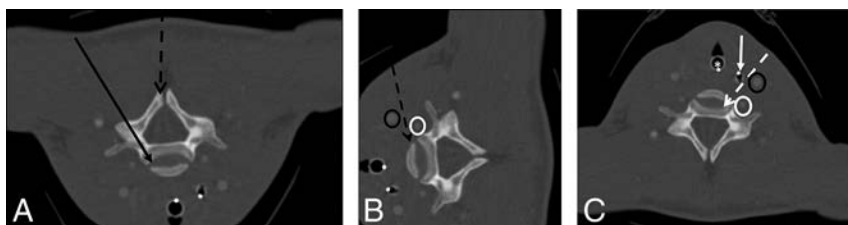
CT-guided cervical spine biopsies were performed using anterolateral, posterolateral, posterior, or lateral approaches. A, CT angiogram of the neck flipped vertically to depict prone positioning for a posterolateral- or posterior-approach cervical spine biopsy. The *black arrow* demonstrates a posterolateral-approach biopsy of the vertebral body or disc. The *dashed black arrow* demonstrates a directly posterior approach to a lesion in the spinous process. B, CT angiogram of the neck rotated to depict decubitus positioning for a lateral-approach biopsy to the vertebral body (*dashed black arrow*). Note that the course of the biopsy needle is between the carotid artery (*black oval*) and vertebral artery (*white oval*). C, CT angiogram of the neck with the patient in a supine position for an anterolateral-approach cervical spine biopsy. The needle (*dashed white arrow*) passes between the intubated trachea (*white asterisk*), nasogastric tube/esophagus (*solid white arrow*), carotid artery (*black oval*), and vertebral artery (*white oval*).
